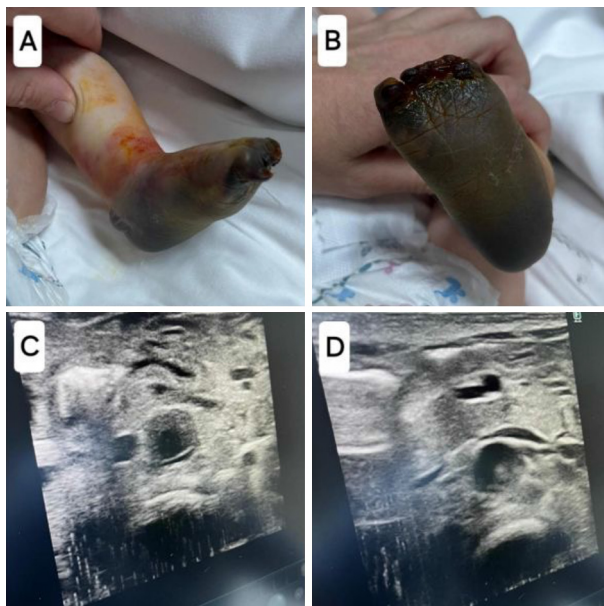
(A, B) The left lower extremity of the first patient upon admission to our clinic. (C, D) Duplex ultrasonography showing the persistence of a thrombus in the aorta.
